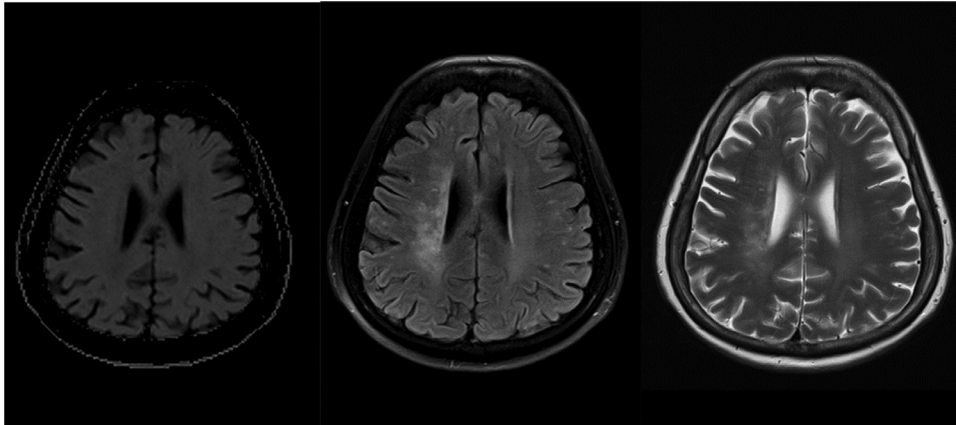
Diffusion-weighted imaging (DWI), fluid-attenuated inversion recovery (FLAIR), T2 of the brain revealed subacute right centrum semiovale and corona radiata infarct (internal watershed zone).
